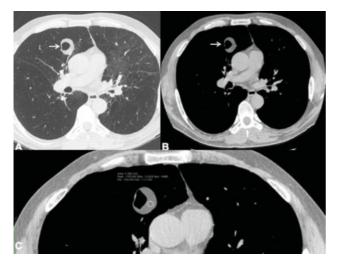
High resolution CT axial images at (A) lung window and (B) mediastinal window confirm a well-defined, rounded centrally cavitated middle lobe (medial segment) lesion (arrows), measuring $3 \text{ cm} \times 2.6 \text{ cm}$ in the maximum transverse dimension. (C) Lung nodule attenuation values are of 120 to 140 UH, clearly indicating the presence of fat. The lesion was highly suggestive of a peripheral cavitated lung lipoma. CT, computed tomography.
